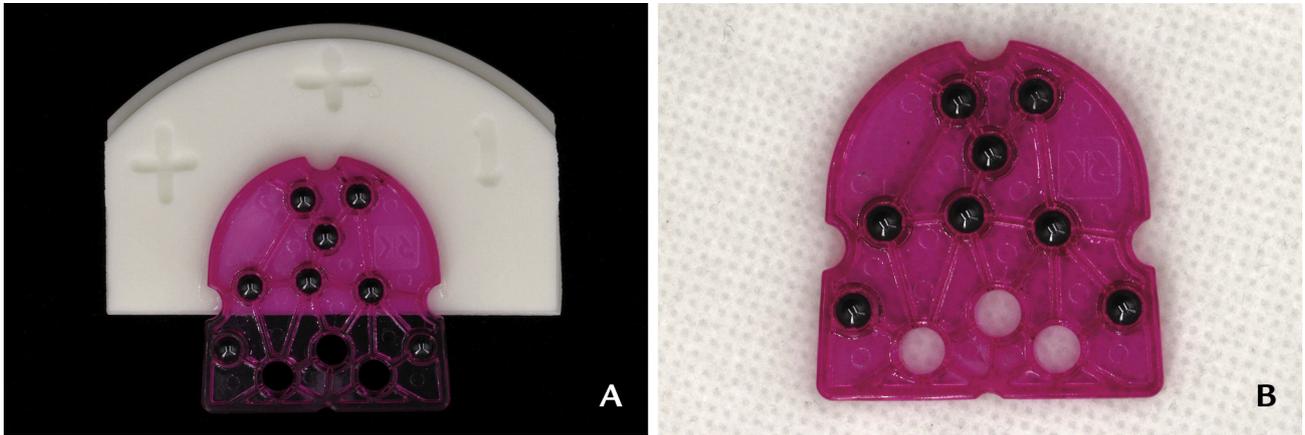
A, Radiopaque radiographic guide. B, Diagnostic template.
